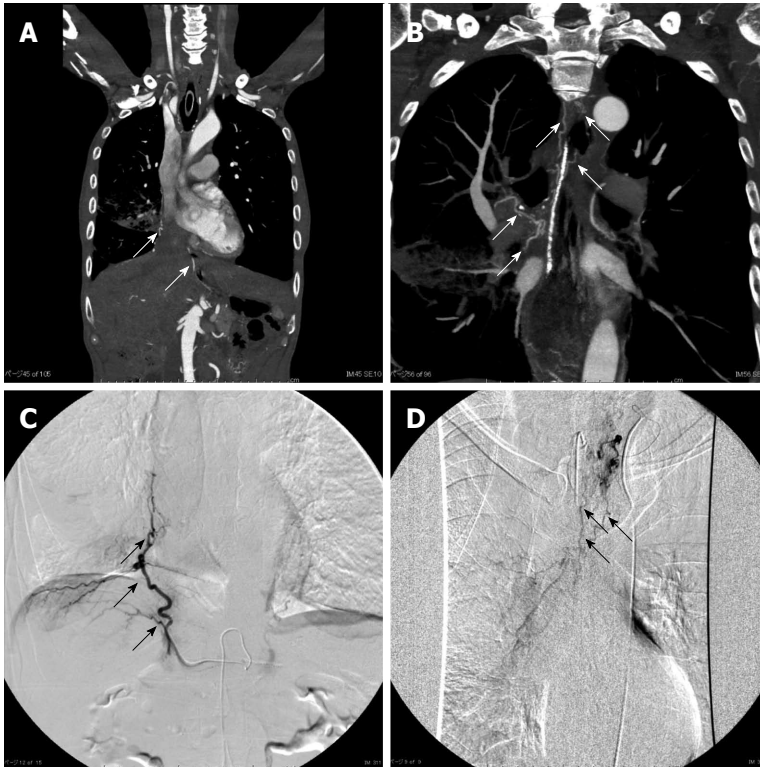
Computed tomography arteriography. A: Computed tomography (CT) arteriography revealed a tortuous artery ascending from the right inferior phrenic artery that arose directly from the aorta (arrows); B: CT arteriography demonstrated several tortuous arteries arising from the left subclavian artery that descended obliquely along the right main bronchus (arrows); C: A collateral right bronchial artery (BA) arising from the inferior phrenic artery. Right inferior phrenic arteriography showed an abnormal tortuous artery (arrows); D: Ectopic BAs arising from the left subclavian artery. Left subclavian arteriography showed abnormal tortuous arteries arising from a root of the left subclavian artery (arrows).
